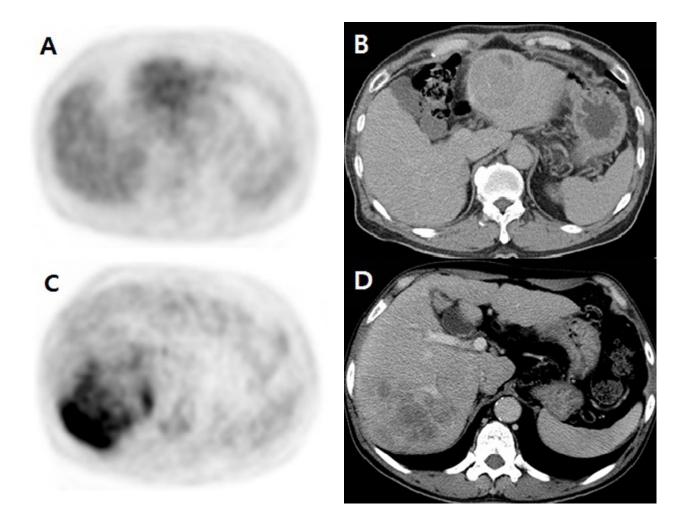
Hepatocellar carcinoma in the left hepatic lobe shows low <sup>18</sup>F-FDG uptake (TLR 1.5). This patient survived for 20 months (A, B). Heterogeneous high <sup>18</sup>F-FDG uptake (TLR 4.3) is seen in the right hepatic lobe and this patient died after 2 months (C, D). Both patients had bone metastasis.
